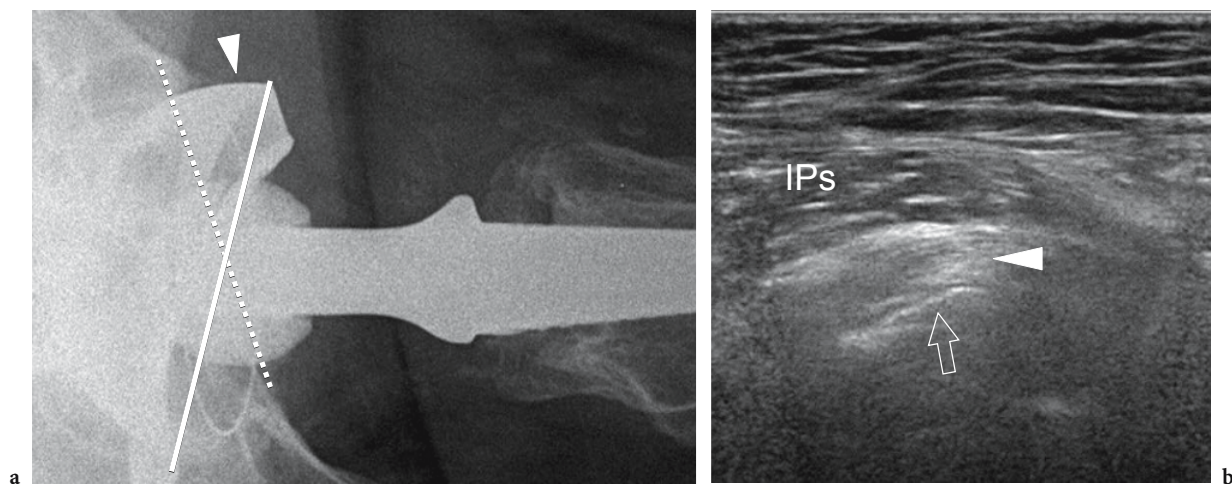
Acetabular cup anteversion. a Arcelin X-ray view of the right hip in a patient who underwent total hip replacement. Note the anterior rotation and protrusion of the anterior edge (*arrowhead*) of the cup. b Longitudinal 12–5 MHz US image demonstrates the impingement of the protruding cup (*arrow*) with the iliopsoas tendon (*arrowhead*). In this particular case, there was no tendon lesion. *IPs*, iliopsoas muscle
